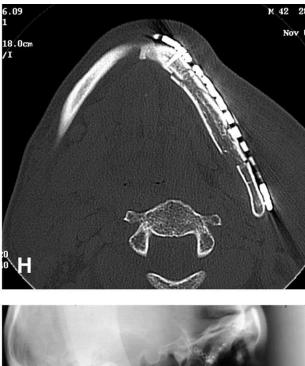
Pretreatment computed tomography scans of a patient who had a multiply-fragmented left mandibular angle/body fracture (*A*, *B*). The fracture was treated open using an extraoral approach (*C*). The patient was placed into MWF while the osseous fragments were reduced using small plates and screws (*D*). A locking reconstruction bone plate was then adapted from the ramus to the symphysis, bridging the comminuted region (*E*). Postoperative CT scans (*F*, *G*, *H*) show that the morphology of the mandible has been reconstructed. Radiographs taken 3 months later show that the fragments have consolidated (*I*, *J*, *K*).
